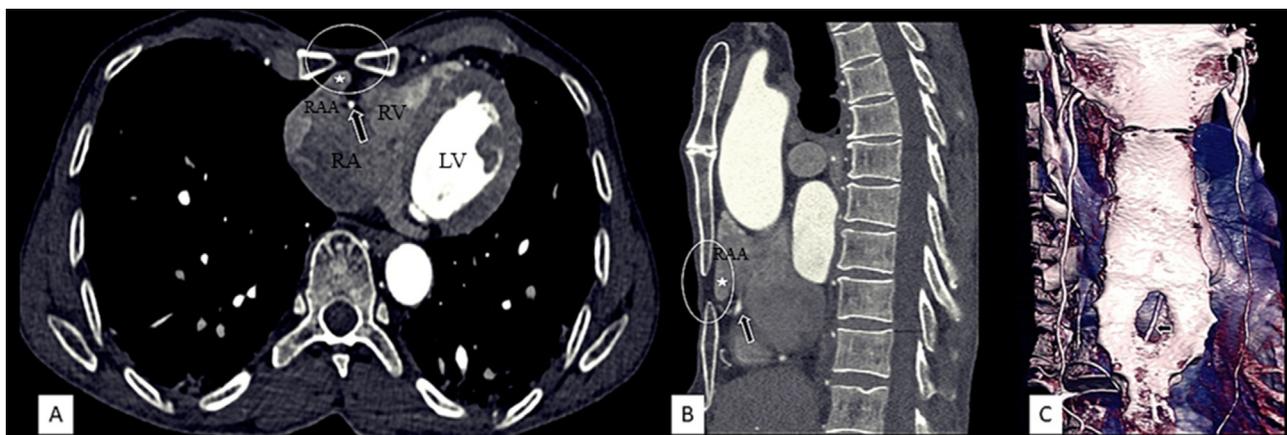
CT angiography images (1A-B) showing sternal foramen (white oval outline), with finger like projection of right atrial appendage (asterisk), and right coronary artery in atrio-ventricular groove (arrow) lying immediately posterior to it. There is significant reduction in antero-posterior diameter of chest (Haller Index 6.62). Volume rendered image (1C) coronal projection showing the sternal foramen at caudal part of corpus sternum with visualization of right coronary artery (arrow) posterior to it. RA-right atrium; RAA-right atrial appendage; RV-right ventricle; LV-left ventricle.
